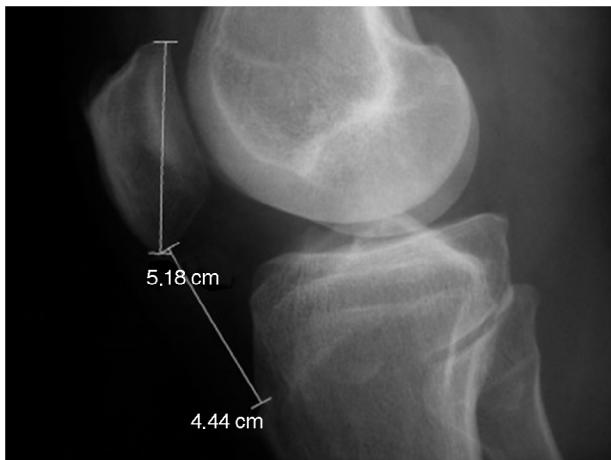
Lateral-view radiograph of the knee. Insall-Salvati calculation.
